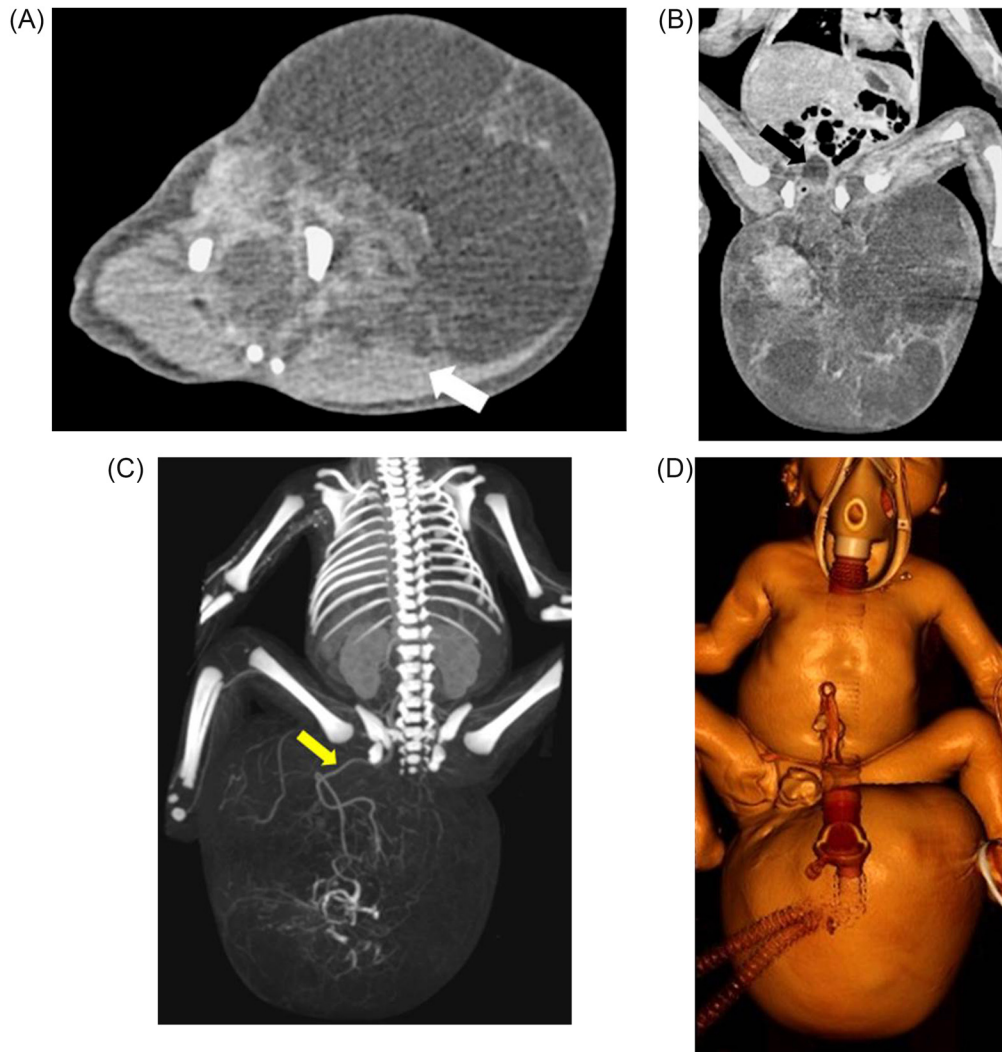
(A-B-C-D) Axial (A) and coronal (B) post-contrast CT images, highlight a voluminous heterogeneous enhancing mass occupying the lower pelvis with mostly external location. The neoplasm contains multiple areas of low attenuation consistent with cysts, separated by thin septa. It is attached to the left gluteus maximus muscle (white arrow in A) and displaces the bladder anteriorly and superiorly (black arrow in B). Right posterior oblique coronal MIP image (C) shows that median sacral artery, particularly apparent (yellow arrow), is the main blood supply of the tumor. Volume-rendered image of the baby (D).
